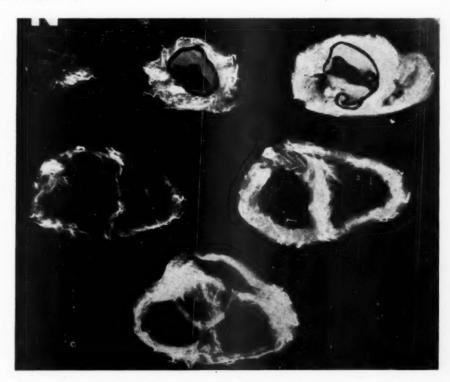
Roentgenogram of the injected heart in Case 81, showing position of the infarct in the septum and the subendocardial portion of the anterior and posterior walls.
